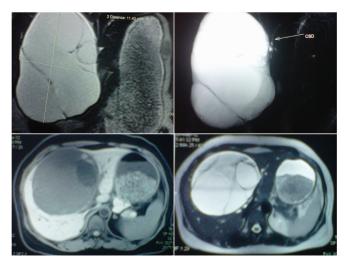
MRI of intrahepatic biliary cystadenoma.
